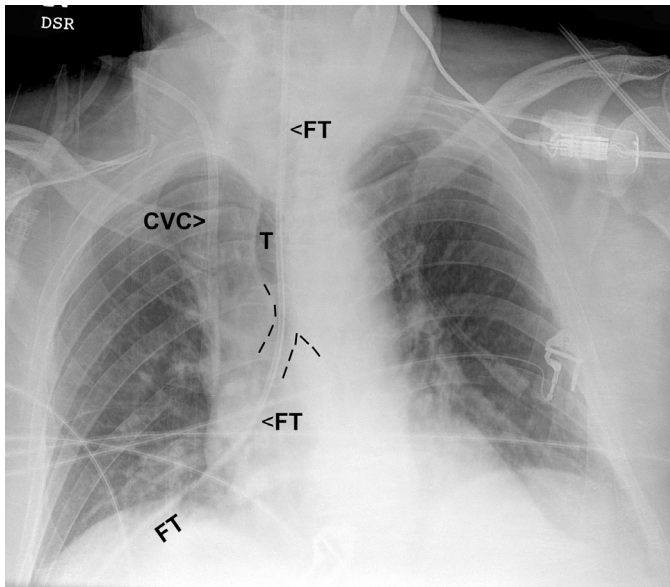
■ Anteroposterior (AP) supine chest x-ray. Feeding tube (FT) courses through the trachea and then down the right bronchial tree to lodge in the peripheral lung.
